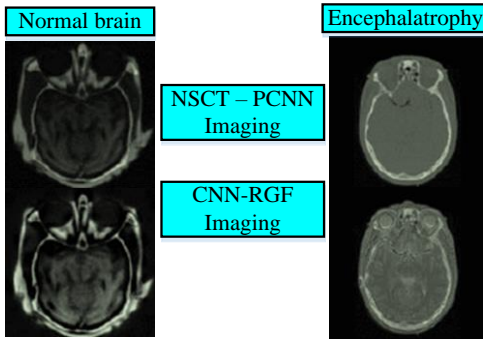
Comparison chart of CT/MRI fusion effect.
